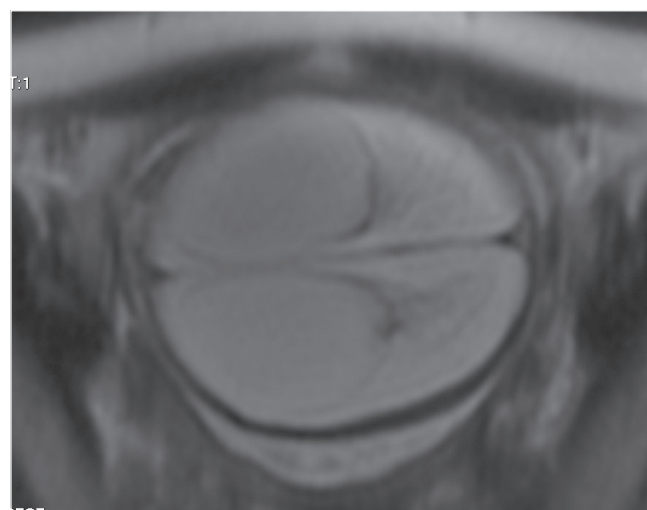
T2-weighted axial MR image demonstrating bifrontal cysts with better clarity. Note associated oligohydramnios and larger field of view.
